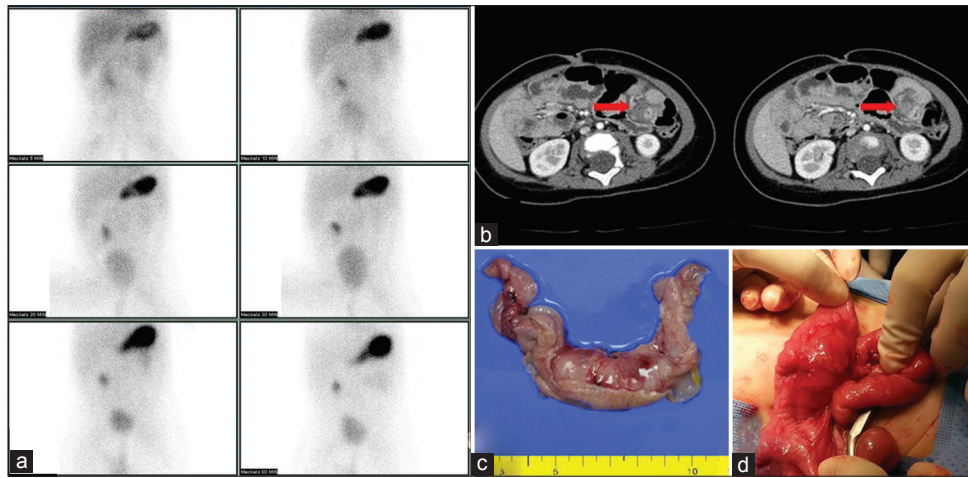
(a) Tc-99m scan of a 6-month-old female, (b) abdominal computed tomographic scan, (c) gross finding of the duplication cyst, and (d) operative finding at surgery.
